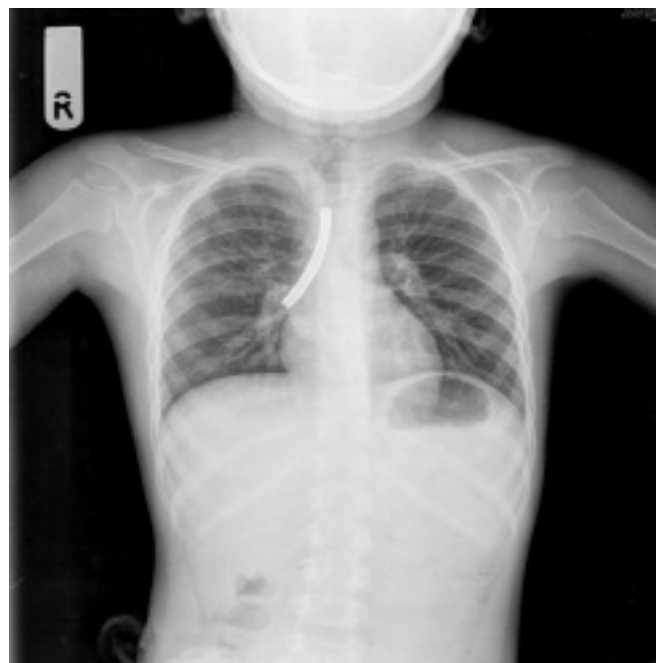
Chest radiograph revealing fractured tracheostomy tube in right tracheobronchial tree
